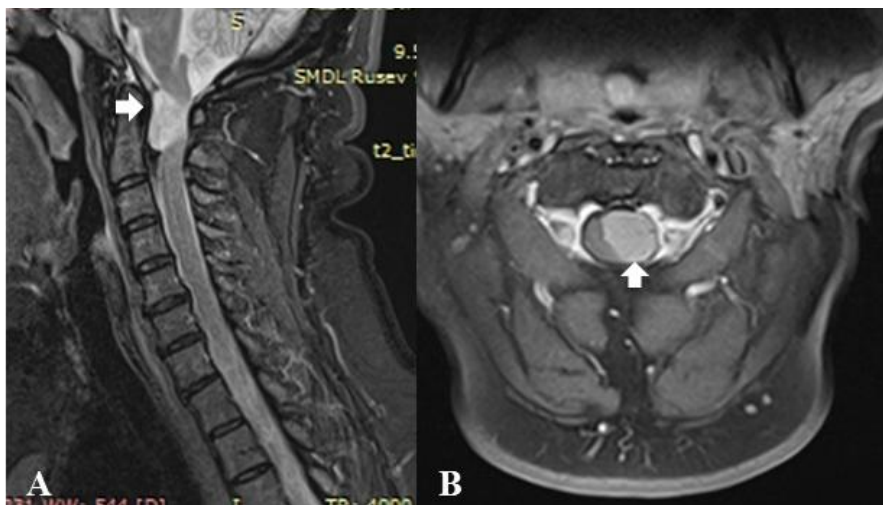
MRI image of ventrolateral meningeoma at the craniospinal junction
